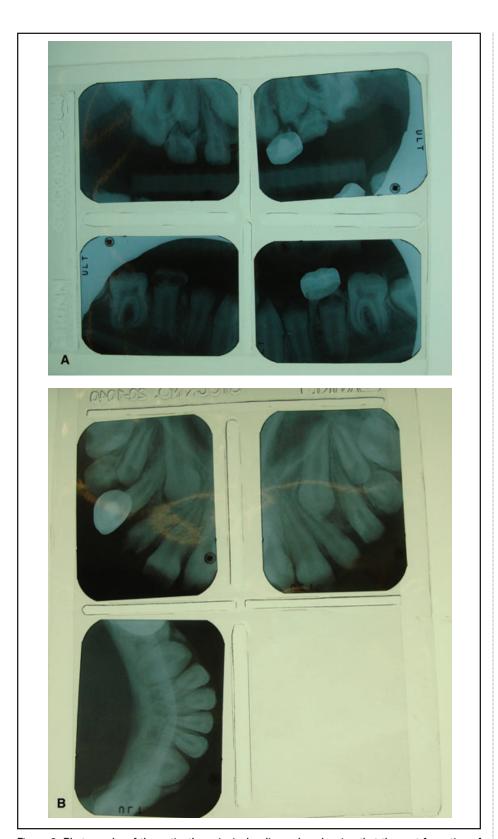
Photographs of the patient's periapical radiographs, showing that the root formation of most of the posterior teeth was about two-third completed. The mandibular occlusal radiograph shows that the mandibular teeth were fully erupted.
